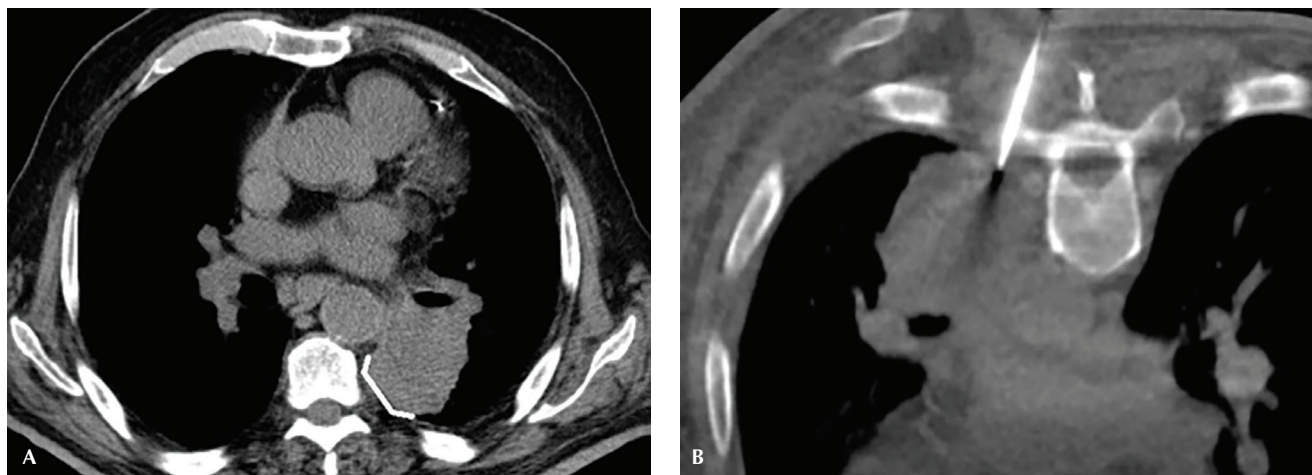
Pleural-contact squamous cell carcinoma in a 68-year-old man. (A) Axial CT image demonstrates the lesion; the white line indicates the pleural contact length. (B) CT-guided core needle biopsy of the lesion
